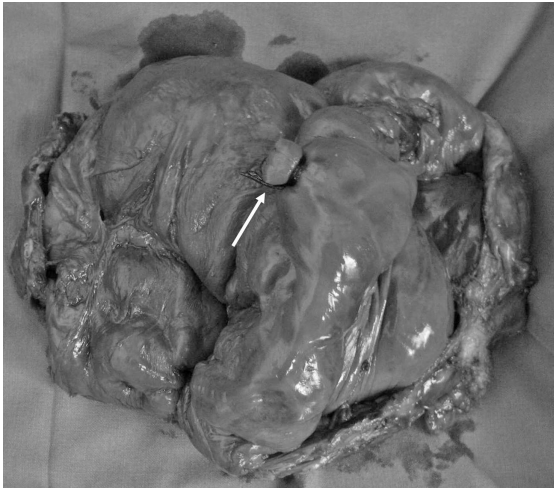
Photograph shows the excised mass, cut open to reveal the umbilical stump (white arrow) that was visible on MR imaging.
